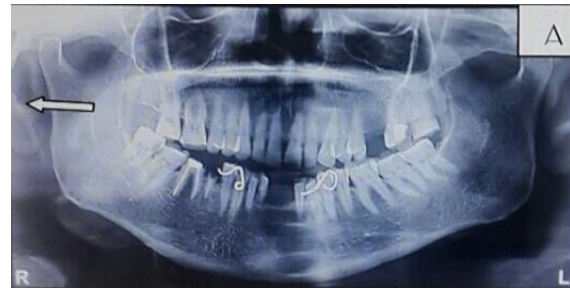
Orthopantogram (a) and x-ray skull anteroposterior view (b) showing elongated styloid (arrow).
